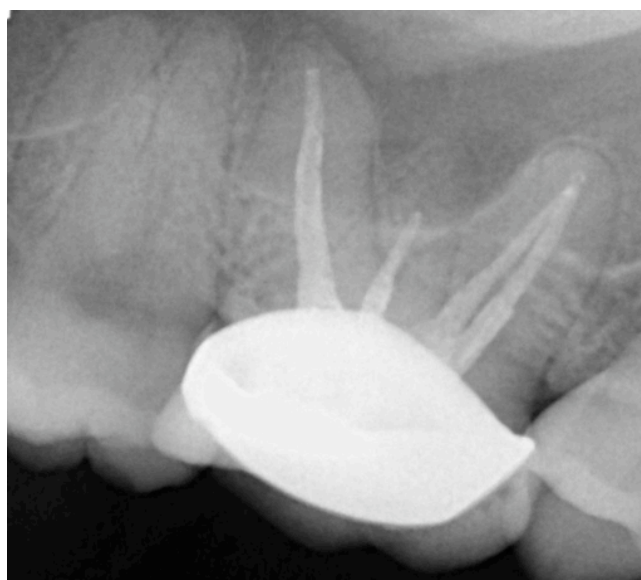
First periapical radiograph of right maxillary first molar (the crack line was not detected).
